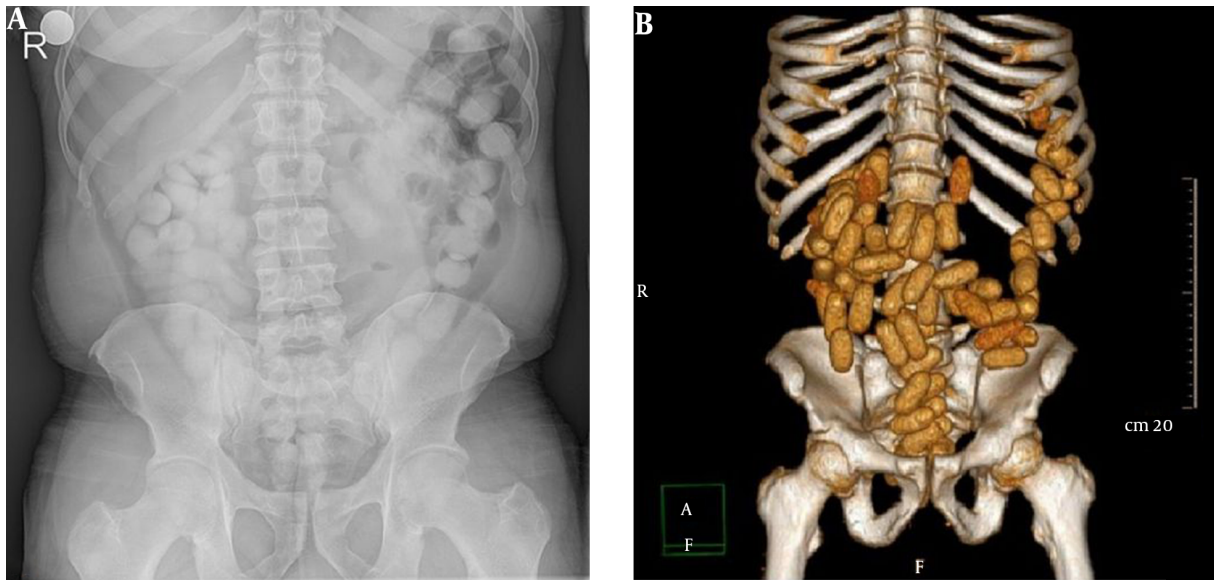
A, a plain abdominal X-ray shows multiple foreign bodies in the gastrointestinal tract; B, 3D CT reconstruction of the abdomen and pelvis shows numerous oval packages of cocaine throughout the gastrointestinal system
